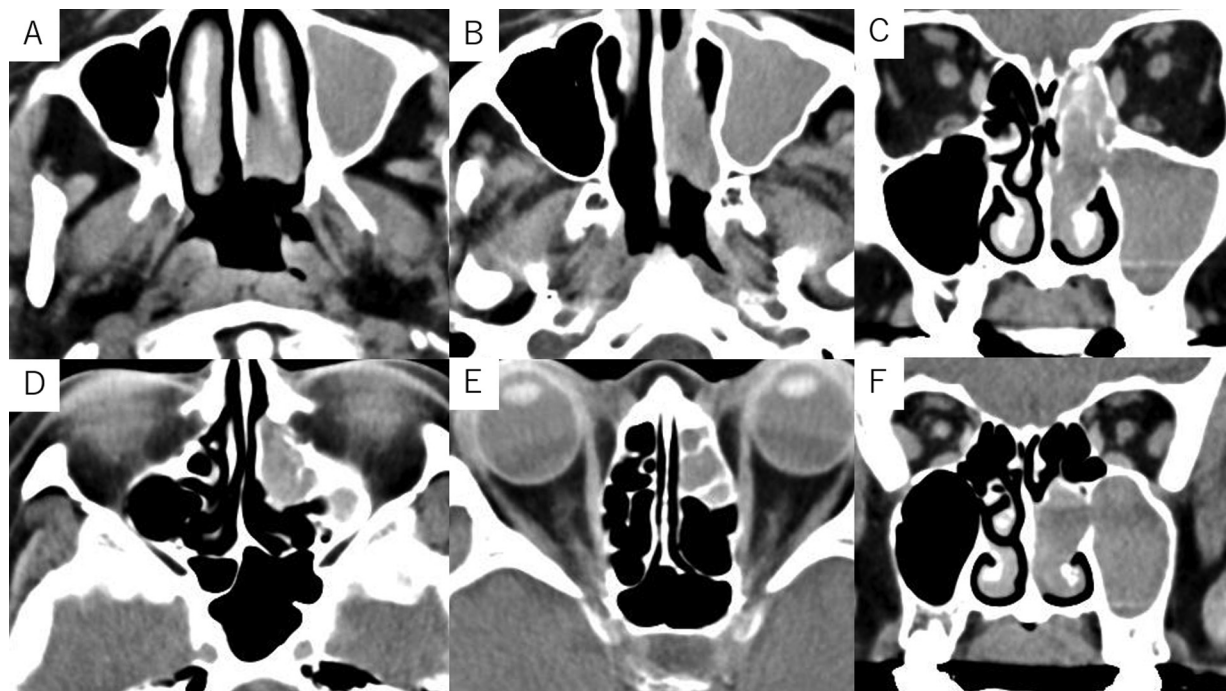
Plain computed tomography of the paranasal sinus. (A,B,D,E) Axial sections. (C,F) Coronal sections. Opacification in the soft part of the left maxillary sinus, frontal sinus, and ethmoidal sinus, with no evidence of bone defect.
